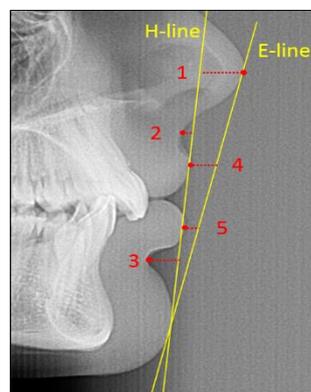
Cephalometric radiograph and soft tissue analysis
